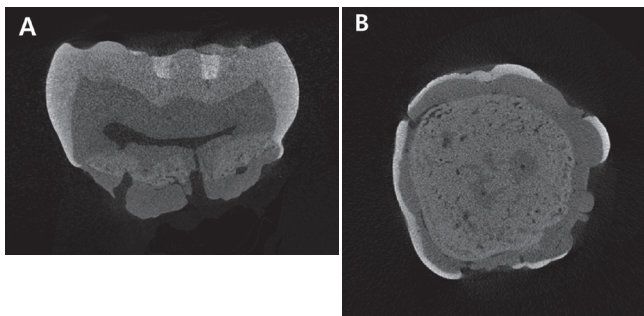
Micro-computed tomographic appearance of the mandibular permanent first molar of patient 1. (A) Bucco-lingual section. Mineralized plate extending to the cemento-enamel junction was observed. Some of the canals penetrated the three layers of the pulpal floor. (B) Horizontal section through the cemento-enamel junction.
